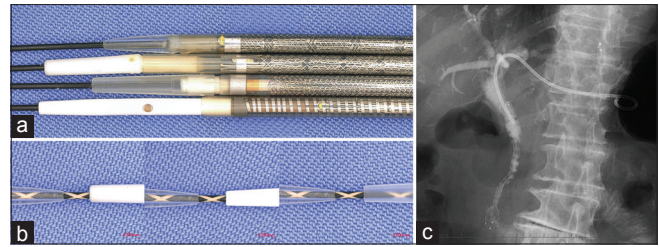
(a) Tips and delivery systems of various ultra-slim self-expandable uncovered metallic stents. Top: ZEOSTENT V (Zeon Medical Inc. Tokyo, Japan; 5.4-Fr maximum diameter), the drawer second: BileRush Selective (Piolax Medical Devices, Yokohama, Japan; 5.7-Fr maximum diameter), the drawer third: Epic™ Biliary Stent (Boston Scientific Japan, Tokyo, Japan, 6.0-Fr maximum diameter), bottom: Zilver635 Biliary Metallic Stent (Cook Medical, Bloomington, IN, USA, 6.0-Fr maximum diameter). (b) Comparison of tips over a 0.025" guidewire with various ultra-slim self-expandable uncovered metallic stents (left side in each: ZEOSTENT V). (a) (left) BileRush Selective (maximum diameter of 5.7 Fr, Piolax Medical Devices, Yokohama, Japan), (b) (middle) ZILVER635 (maximum diameter of 6.0 Fr, Cook Medical, Bloomington, IN, USA), (c) (right) Epic™ Biliary Stent (maximum diameter of 6.0 Fr, Boston Scientific Japan, Tokyo, Japan). (c) Radiograph showing EUS-guided antegrade stenting with a novel 5.4-Fr uncovered self-expandable metallic stent combined with EUS-guided hepaticogastrostomy with a novel dedicated 7.0-Fr plastic stent
